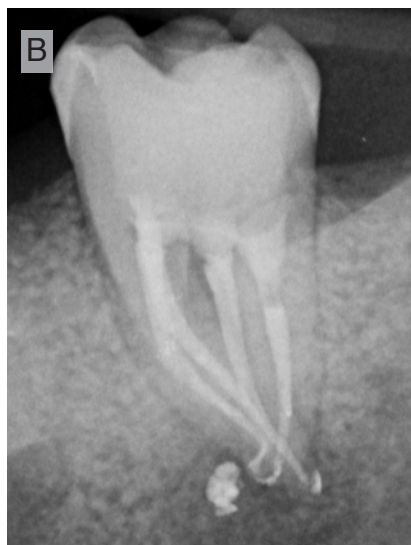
Final radiograph: A) Orthoradial. B) Distoradial.
